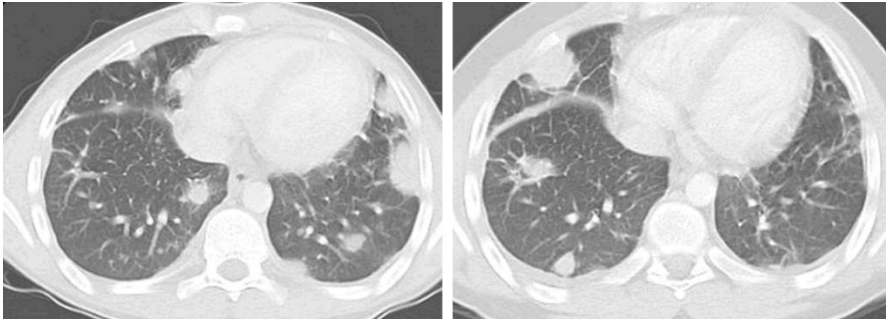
Multiple plain lung nodules in a patient with granulomatosis with polyangiitis (axial CT images).
